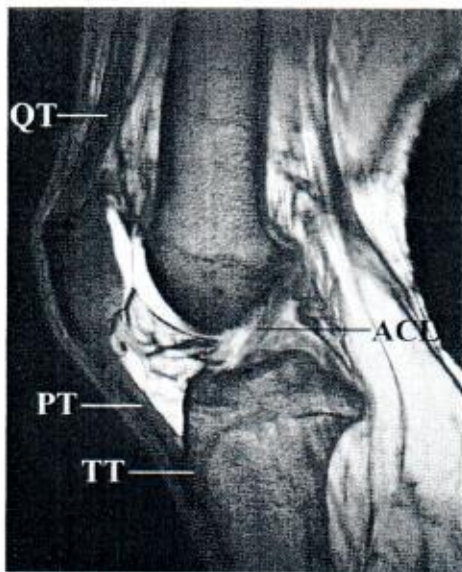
Normal MR anatomy in the sagittal plane of the extensor apparatus, showing the separate layers of the quadriceps tendon (QT). The patella is attached to the tibial tuberosity (TT) by the patellar tendon (PT). ACL, Anterior cruciate ligament. There is a bright signal from the patellar and femoral cartilage on this T1-weighted Flash 2D sequence
